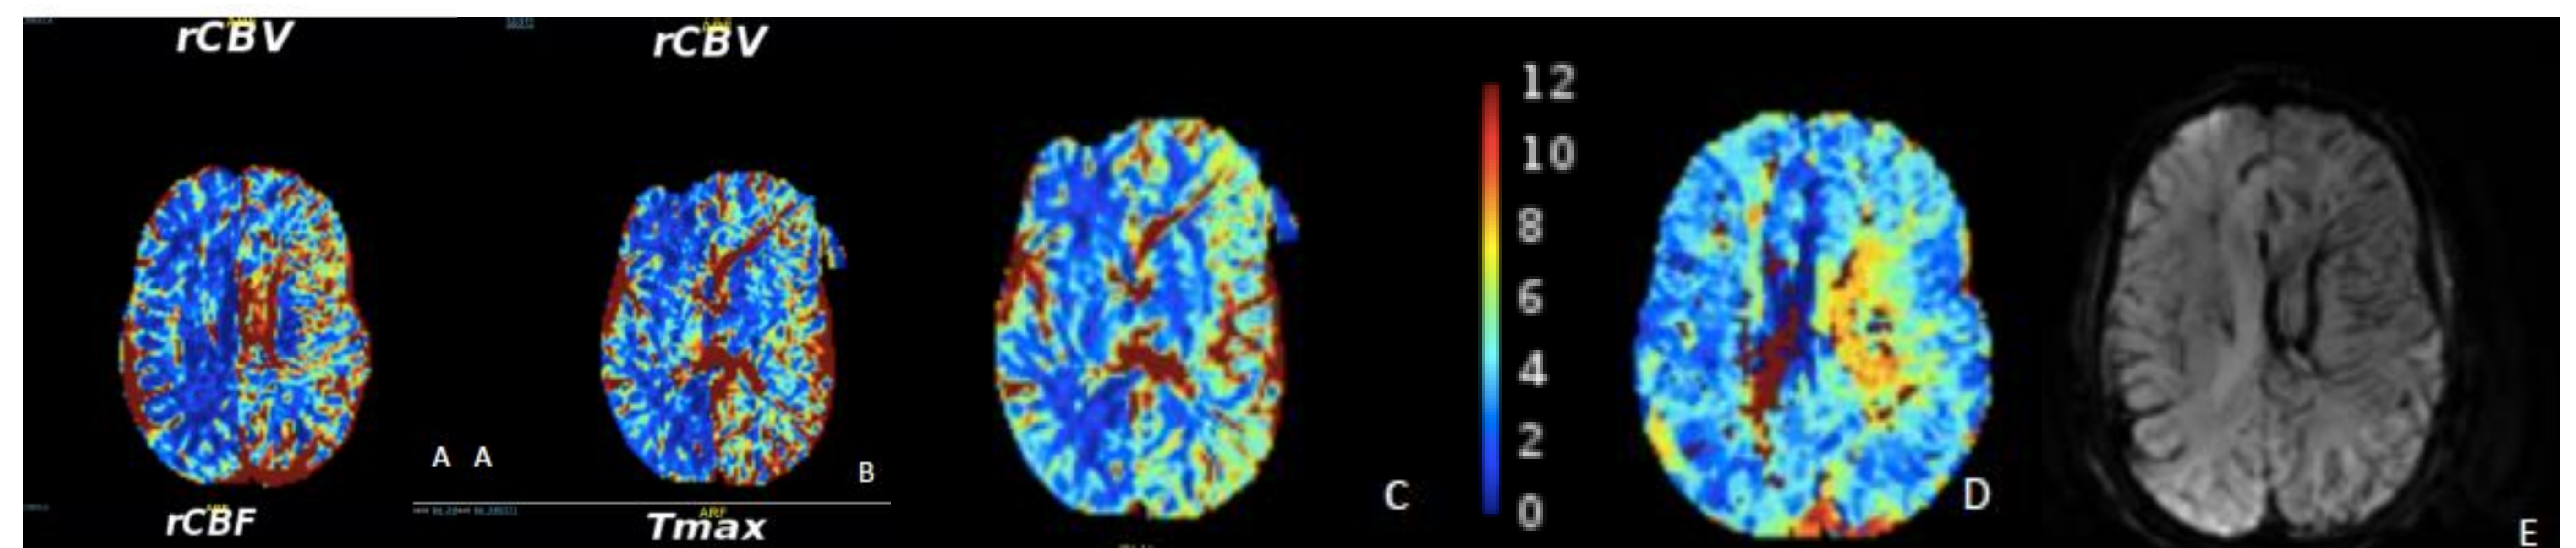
MRI Brain perfusion. Increased cerebral blood flow and blood volume throughout the cortical surface in the left hemisphere compared to the right (A, B, C). There is elevated Tmax in the left cerebral hemisphere likely due to venous congestion (D). RAPID AIF/VOF (E), prominent deep medullary and thalamostriate veins.
